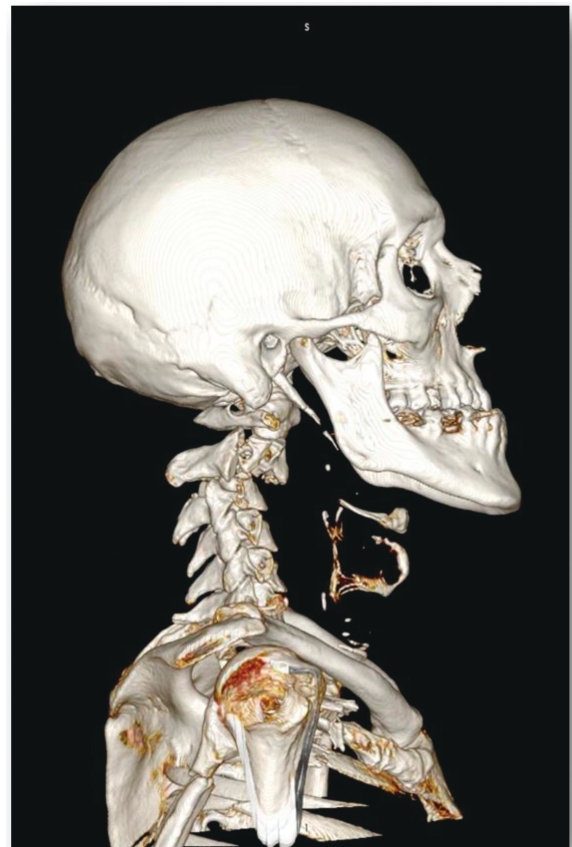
Example of a postmortem computed tomography image of trauma case: Displaced fractured neck sustained by road traffic collision.
